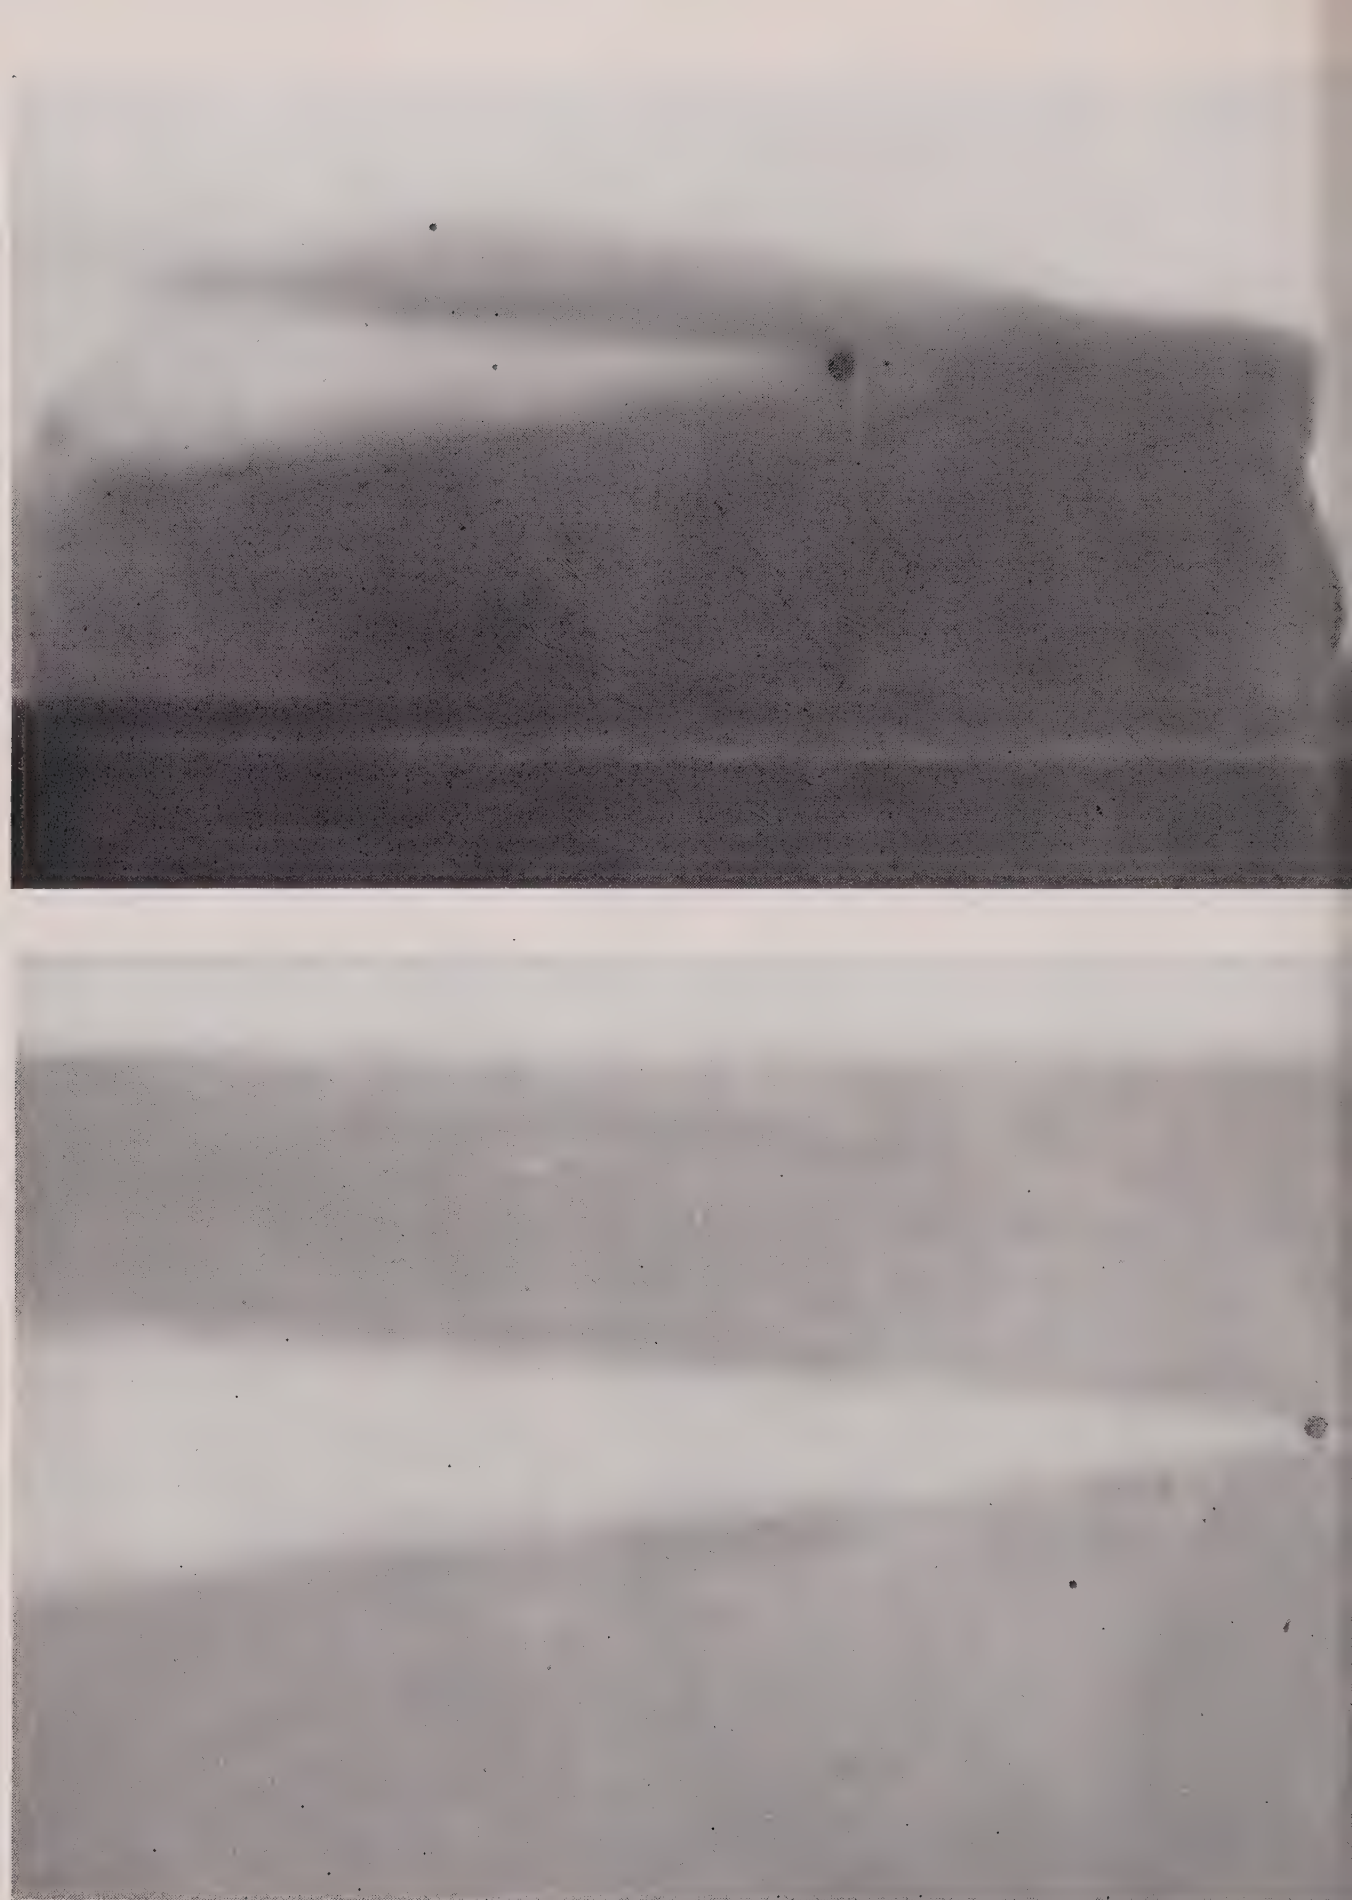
Microsecond roentgenograms of a $\frac{4}{32}$ -inch steel sphere passing through butcher's meat and through water.*
